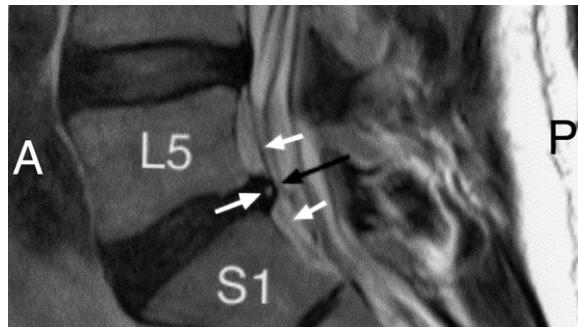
Lumbar MRI parasagittal T2-weighted image. Note: (i) there is early desiccation of the L4–5 and L5–S1 intervertebral discs, (ii) there still is a significant posterior disc protrusion at the L5–S1 level (large black arrow) that presses upon the pain sensitive anterior part of the dural tube (small white arrows) and, (iii) there still is a high intensity zone representing an annular tear/fissure in the disc protrusion (white arrow). (Compare Fig. 24.3 which is almost in the same parasagittal plane.) The highly probable epidural haematoma has resolved.
